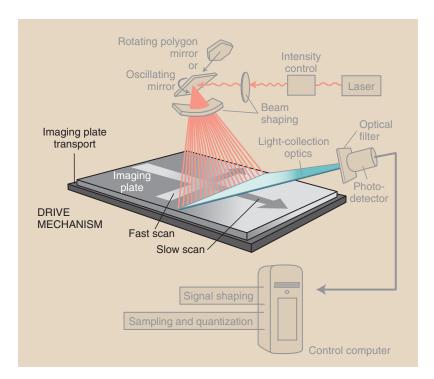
The drive mechanisms of the computed radiography (CR) reader move the imaging plate (IP) slowly along its long axis, while an oscillating beam deflection mirror causes the stimulating laser beam to sweep rapidly across the IP.
